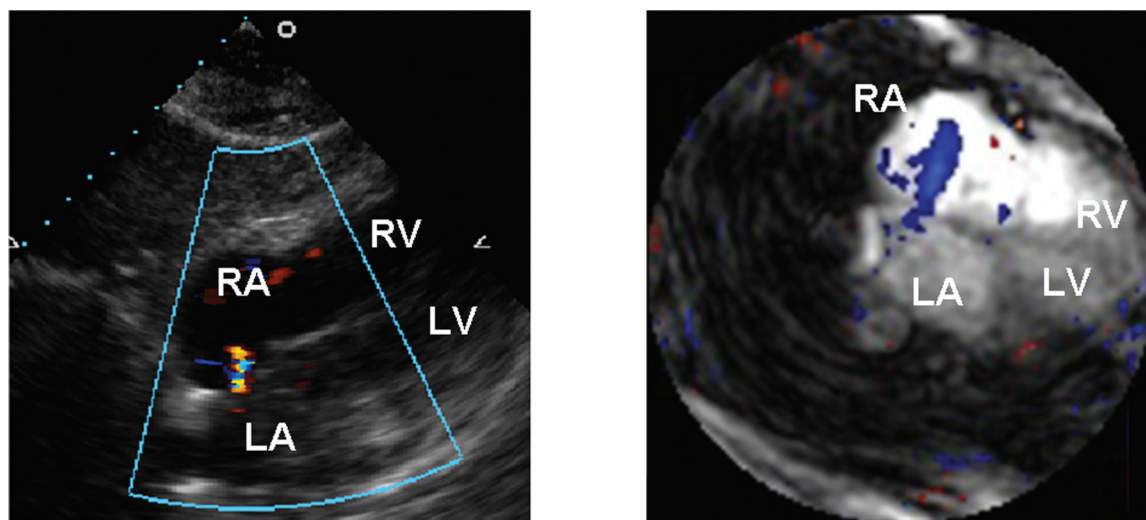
Small secundum ASD. A small aliased jet extending into the right atrium (RA) is seen on echocardiography (left). A blue jet without aliasing is clearly seen extending across the atrial septum into the RA on real-time color-flow CMR (right). LA-left atrium. LV-left ventricle. RV-right ventricle.
